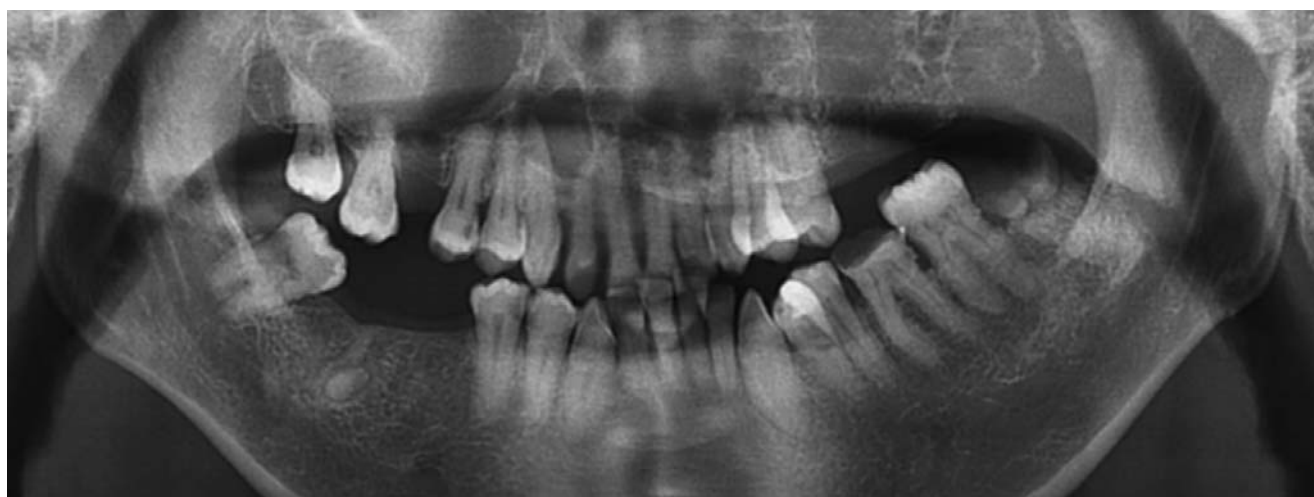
Panoramic radiograph revealing ill defined multilocular lesion in maxilla with complete involvement of left maxillary sinus and lesion crossing the midline towards the right
